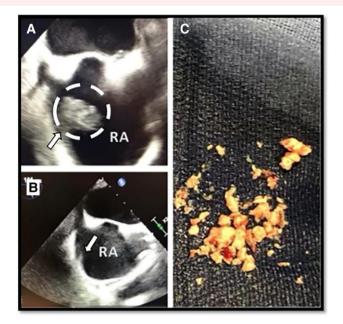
Successful valvular aspiration and debulking of eustachian valve vegetation. (A) Trans-oesophageal echocardiogram surveying the large vegetation (located within the dashed circle) and eustachian valve (indicated by the arrow). (B) Trans-oesophageal echocardiogram post AngioVac[®] shows no further residual mass. (C) Suctioned vegetation collected from the AngioVac[®] filter.
